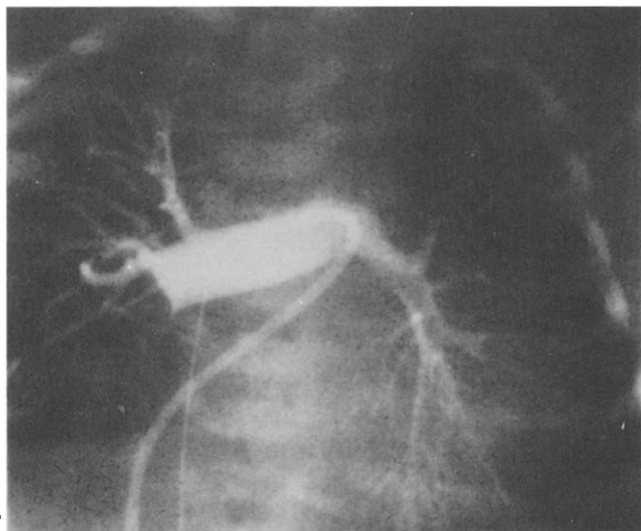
Chest X-ray film taken 1 hour after balloon occlusion of the right lower pulmonary artery. The balloon was inflated with a solution containing contrast material. The cardiac silhouette has markedly decreased in size from the previous examination and the cardiothoracic ratio is 0.51.
